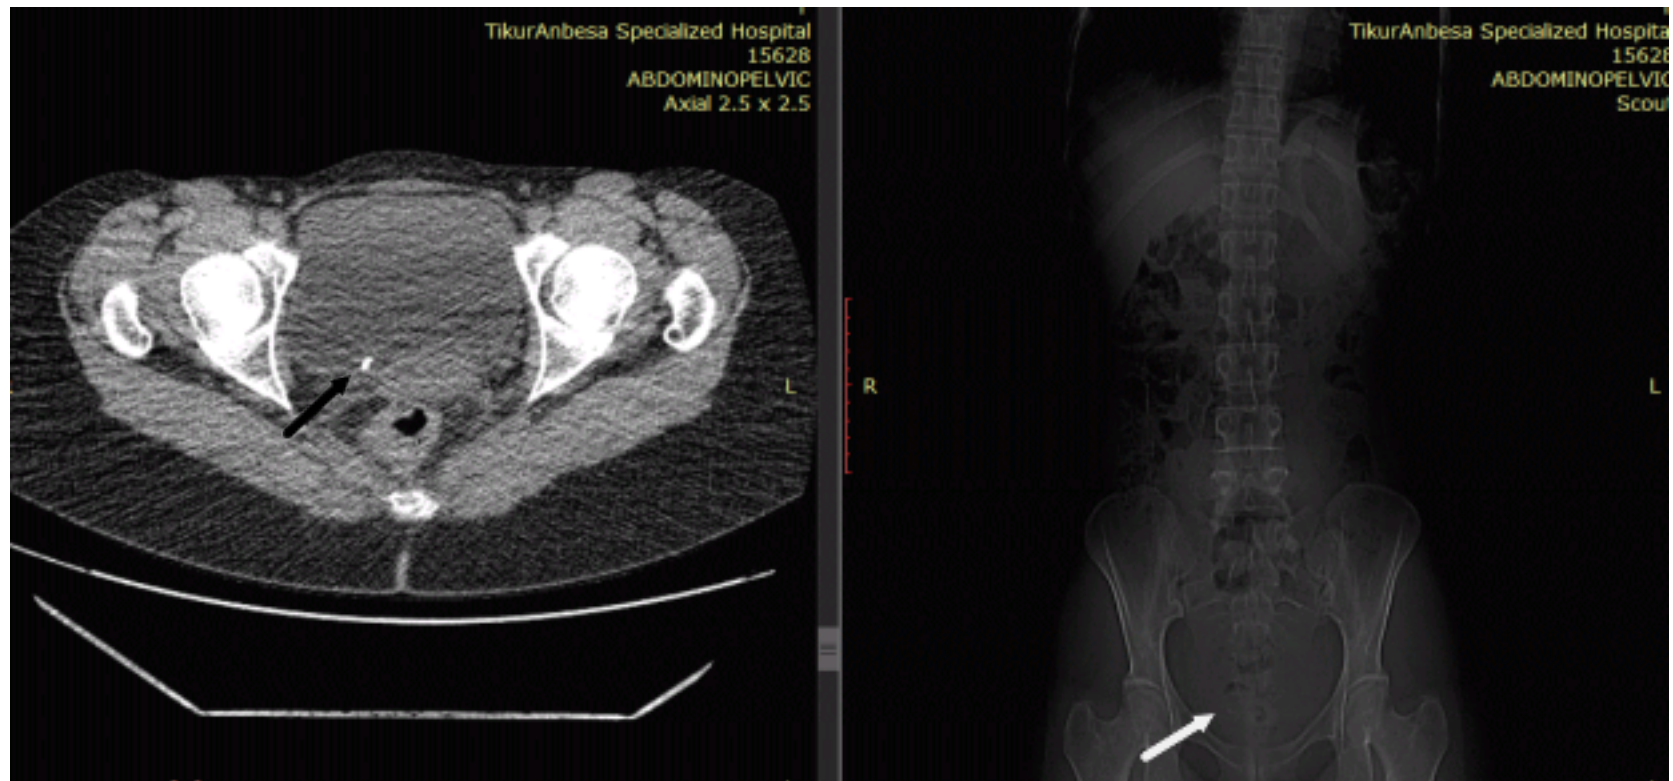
calculus in mid ureter (white arrow) on (a) an unenhanced helical CT for kidney, ureter and bladder, is clearly visible (b) the scout radiograph.
